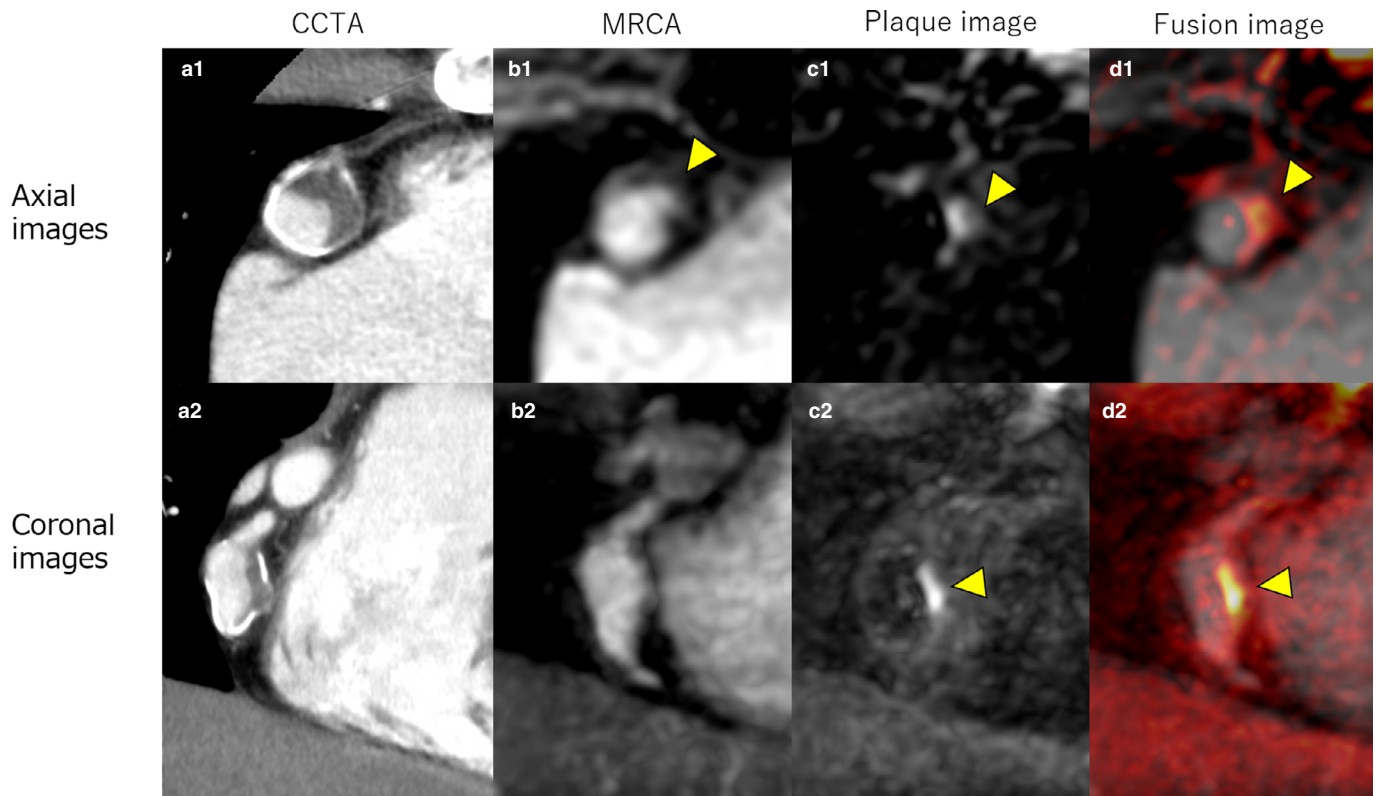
(a) CCTA showed wall thrombus in an RCA aneurysm. (b) MRCA at the same level of CCTA showed thrombus was unclear (yellow arrowhead), but vascular lumen was irregular. (c) Thrombus was hyperintense in PI (yellow arrowhead). (d) In the fusion image, the thrombus (yellow arrowhead) in the aneurysm was clearly visualized by superimposing PI (c) on MRCA (b). CCTA, coronary computed tomography angiography; RCA, right coronary artery; MRCA, magnetic resonance coronary angiography; PI, plaque imaging.
